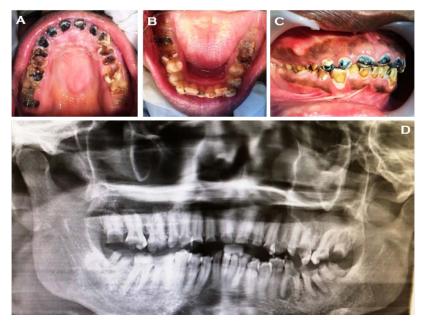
(A) Maxillary arch showing decayed teeth (B) Mandibular arch with decayed teeth (C) Teeth in centric occlusion (D) Orthopantomograph showing the extent of decay and periapical
